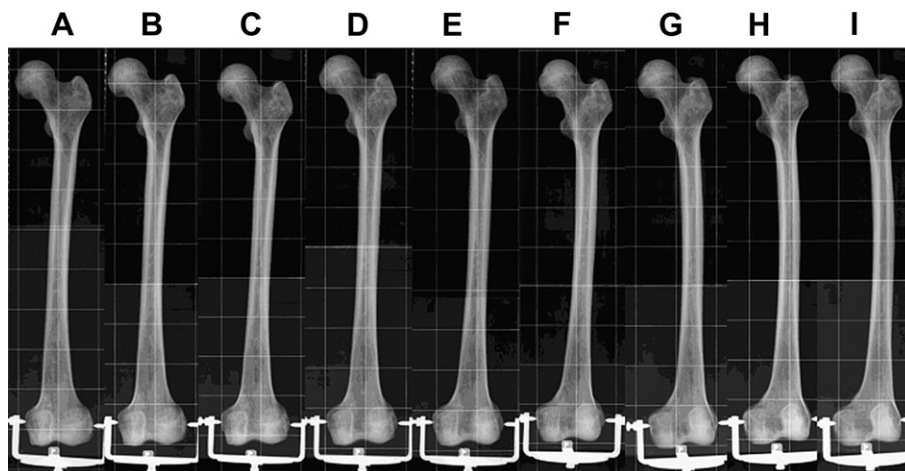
Nine standard anteroposterior radiographs of left femur taken from 20° IR to 20° ER, which demonstrated the changes in appearance of the lesser trochanter. (A) IR 20°; (B) IR 15°; (C) IR 10°; (D) IR 5°; (E) neutral; (F) ER 5°; (G) ER 10°; (H) ER 15°; and (I) ER 20°. ER = external rotation; IR = internal rotation.
